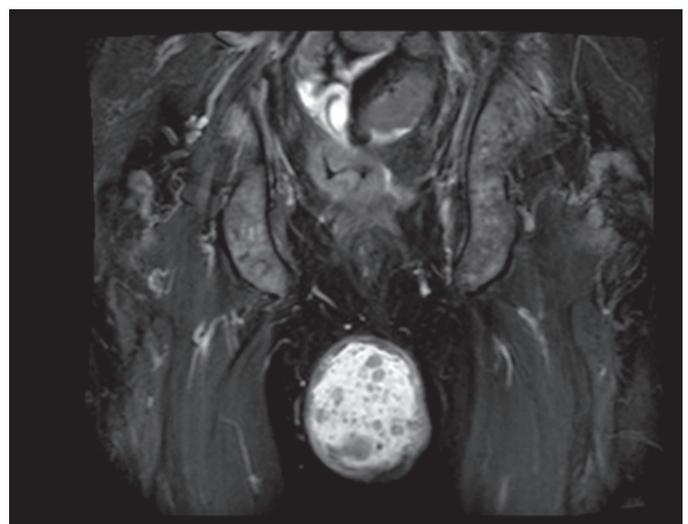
STIR magnetic resonance imaging scan coronal view showing multiple cystic masses within the right testicle.
